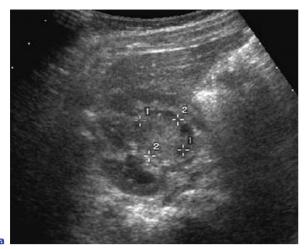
Focal pseudotumoral pyelonephritis in a 15-month-old girl presenting with fever. Homogeneous small hyperechoic area on US (a) and hypoattenuating area on enhanced CT scan (b) without mass effect. No biopsy performed. Urinary tract infection diagnosis was based on bacteriuria (E. coli) and disappearance of the lesion on US under antibiotic therapy
